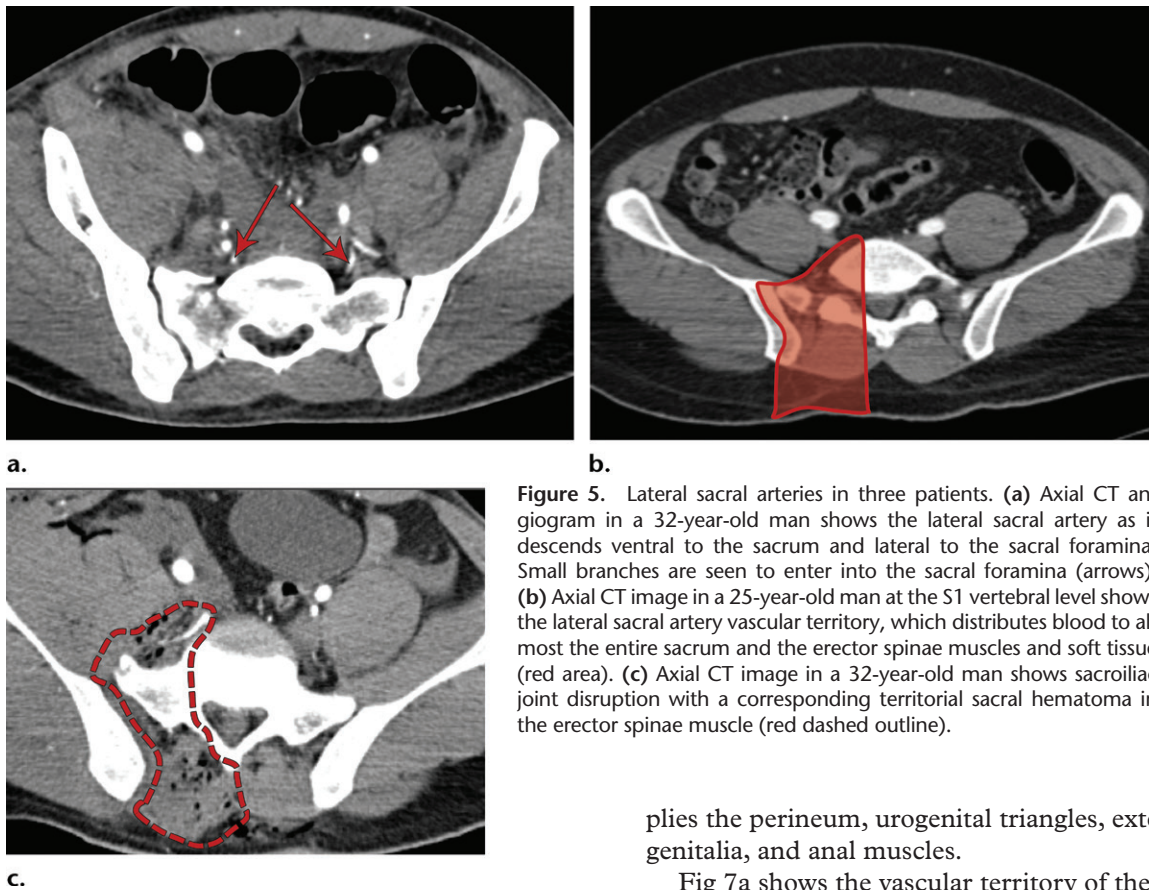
Lateral sacral arteries in three patients. (a) Axial CT angiogram in a 32-year-old man shows the lateral sacral artery as it descends ventral to the sacrum and lateral to the sacral foramina. Small branches are seen to enter into the sacral foramina (arrows). (b) Axial CT image in a 25-year-old man at the S1 vertebral level shows the lateral sacral artery vascular territory, which distributes blood to almost the entire sacrum and the erector spinae muscles and soft tissue (red area). (c) Axial CT image in a 32-year-old man shows sacroiliac joint disruption with a corresponding territorial sacral hematoma in the erector spinae muscle (red dashed outline).
